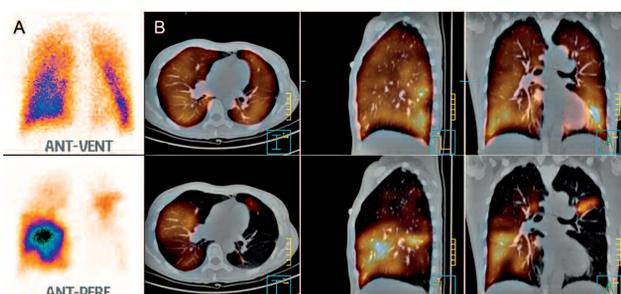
Radionuclide lung ventilation/perfusion scintigraphy shows a wide range of bilateral pulmonary emboli. A: Planar images, anterior position. B: Transaxial, sagittal and coronal views of integrated SPET/CT images (upper row: ventilation; lower row: perfusion).
